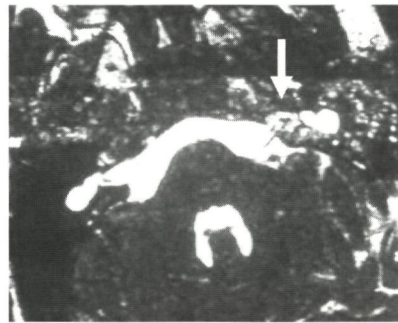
Patient 10a, MRI, axial view: bilateral common cavities, intact cribriform plate (*arrow*).
